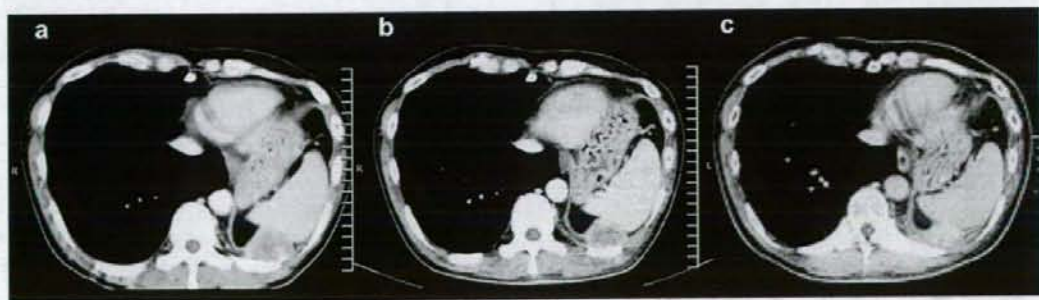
(a) Pretreatment CT images. (b) Follow-up CT after 1 month showing slight regression of the tumors behind the spleen. (c) Follow-up CT after 3 months showing regression of the tumors judged as PR.
